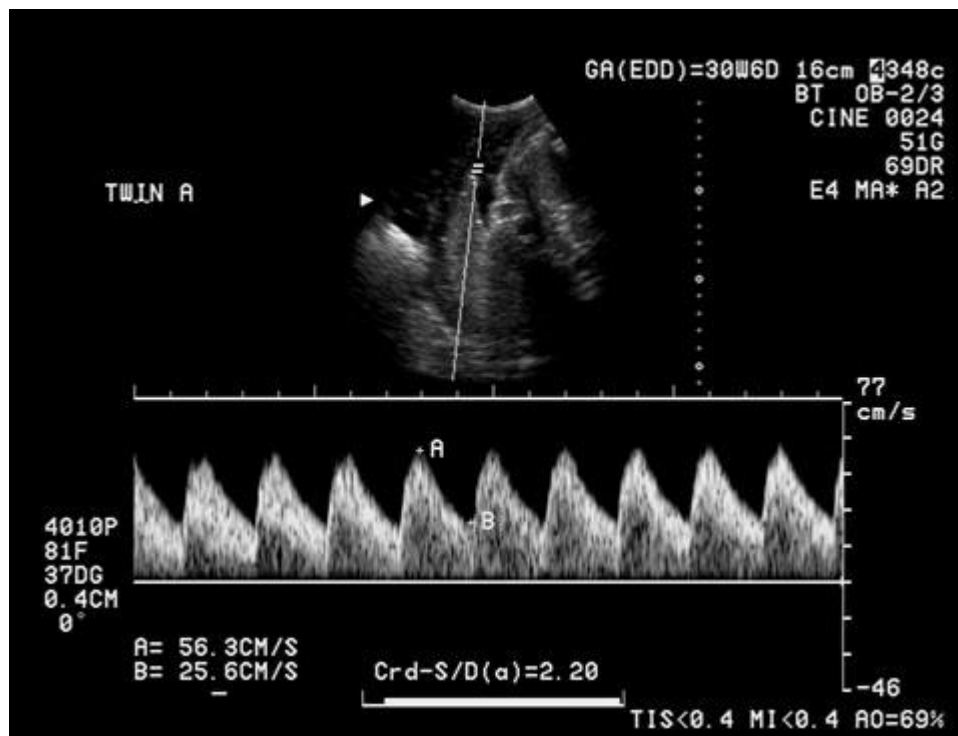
NORMAL UMBILICAL ARTERY DOPPLER
